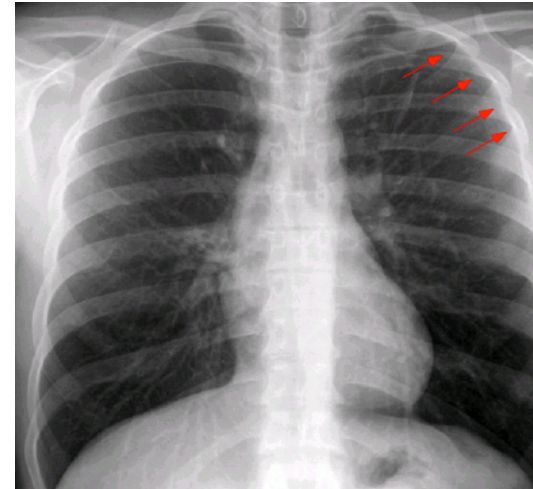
Chest X-ray demonstrating a small left apical pneumothorax. The visceral pleural line is marked by the arrows.
